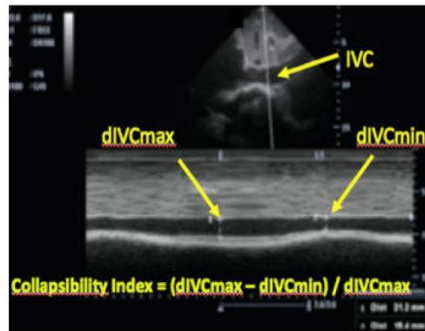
Obtaining the collapsibility index and measuring the inferior vena cava (IVC) using ultrasound is shown in Figure 4. The two-dimensional image of the inferior vena cava (IVC) with the right atrium shifted to the left may be seen in the panel above, while the M-mode image below reveals fluctuations in diameter due to respiratory factors. [14] defined D IVC max and d IVC min as the maximum and minimum diameters of the inferior vena cava, respectively.
